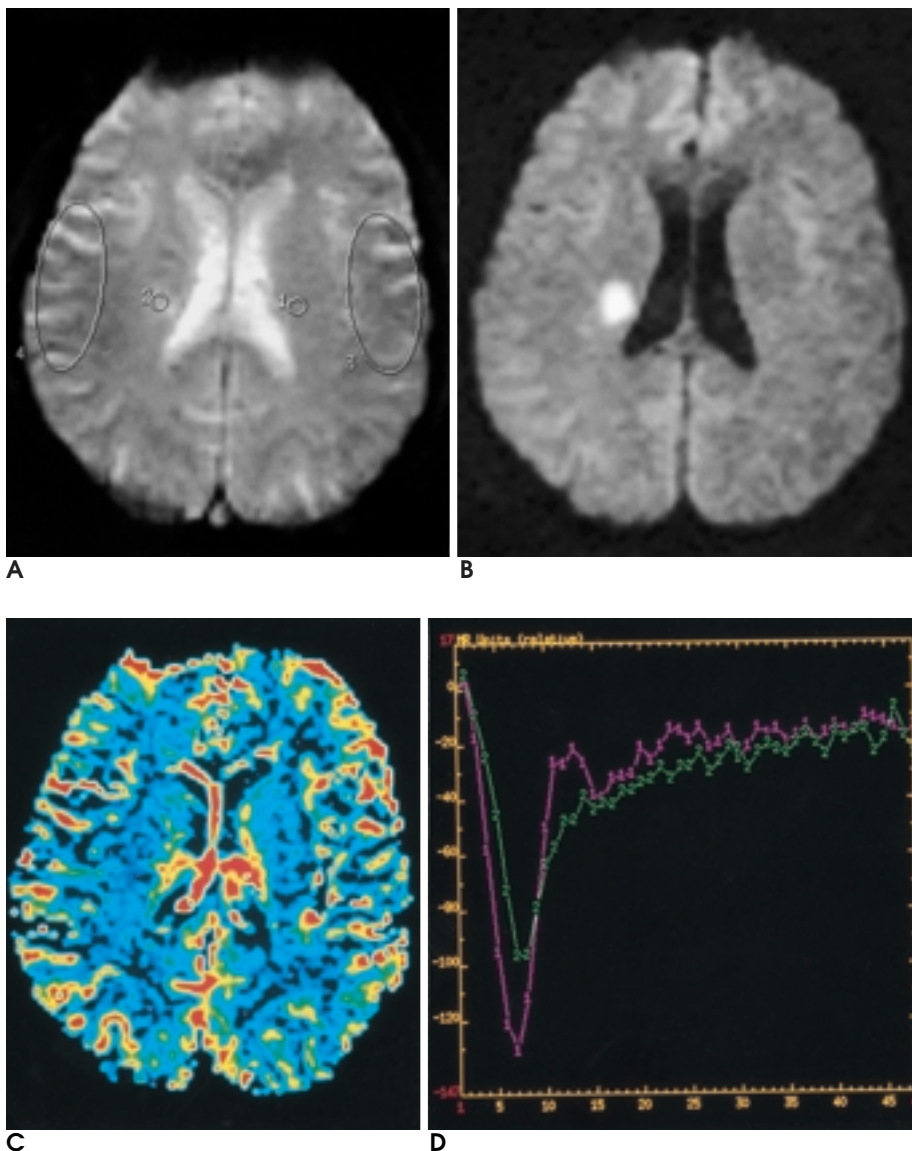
49-year-old man with dysarthria (case 1). T2*-weighted image(A) and DWI(B) shows infarcted lesion in right basal ganglia. rCBV map(C) shows decreased perfusion area in right basal ganglia, and time-intensity curve(D) reveals decreased perfusion on lesion(number 2), as comparison to that on contralateral region(number 1). Calculated rCBV ratio of lesion is 0.73.
